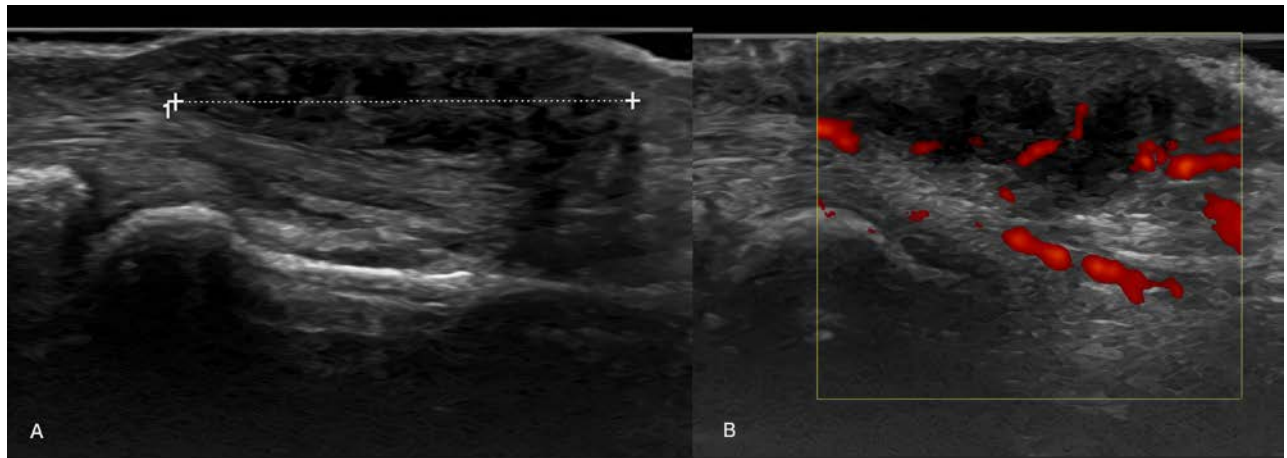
Ultrasound of the finger at the level of the proximal interphalangeal joint demonstrates a localized extra-articular TSGCT. The lesion appears as a solid hypoechoic nodular mass adjacent to the tendon sheath (A) with intralesional vascularity on colour Doppler (B).
